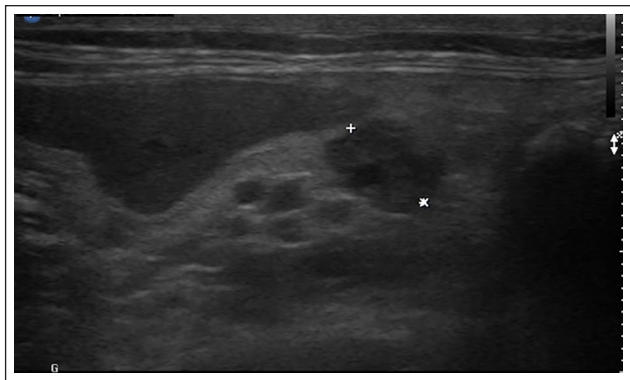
Ultrasound image of the pancreas
